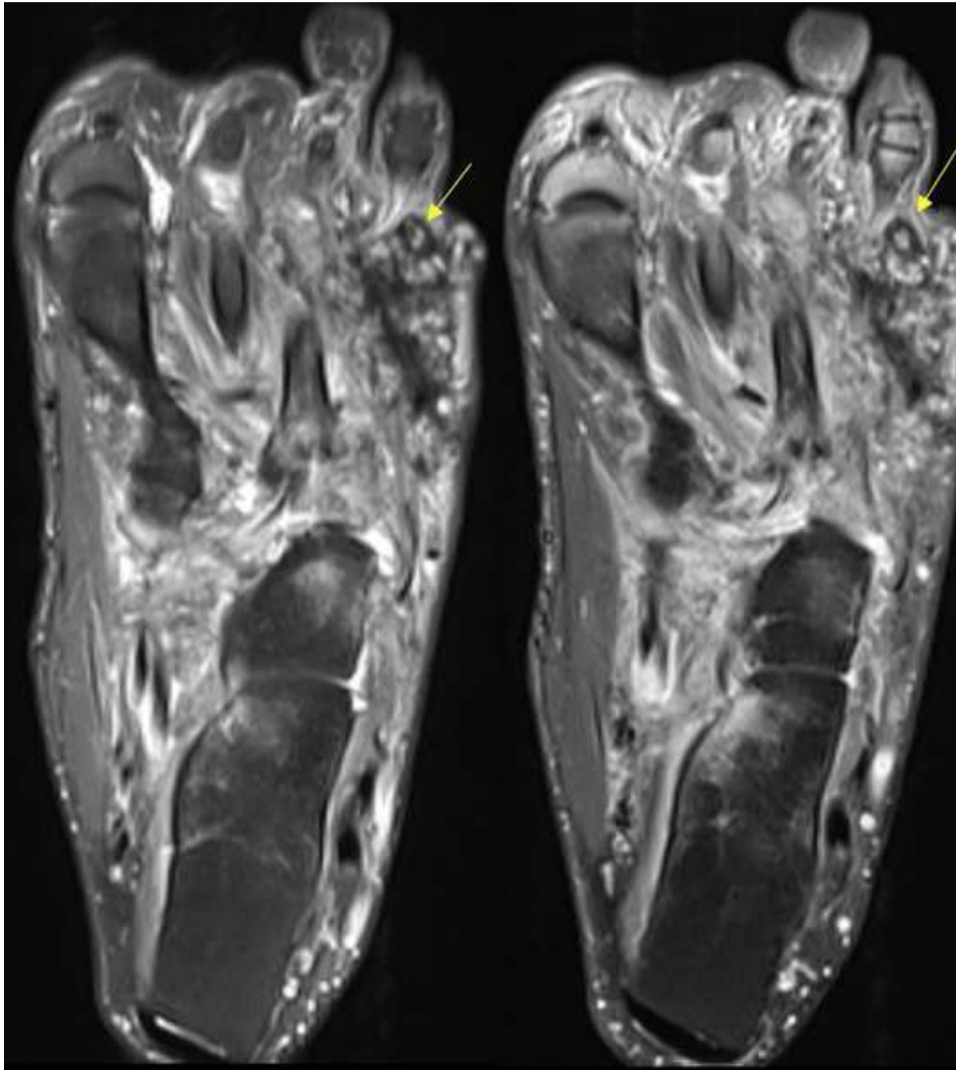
Case 2. Coronal MRI sections in proton data weighting (A) and fat-suppressed T1 weighting after intravenous gadolinium injection (B), showing the previously described mycetoma grains with the “dot in a circle sign” and effusion of the 4 last metatarsophalangeal joints as well as synovial thickening. Note also the bone-marrow edema in the cuboid as well as the 4th and 5th metatarsal bones, possibly consistent with osteomyelitis.
